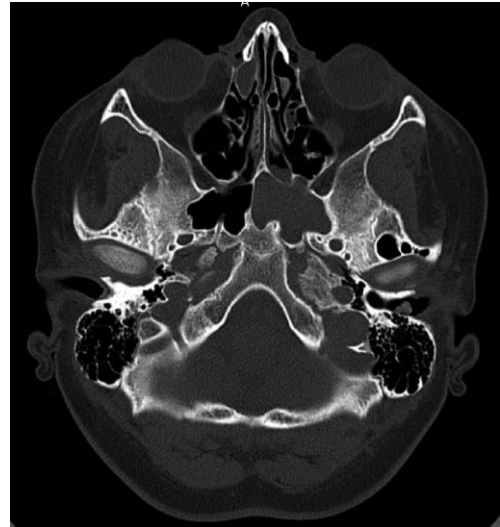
CT scan - total opacification of the left sphenoid
